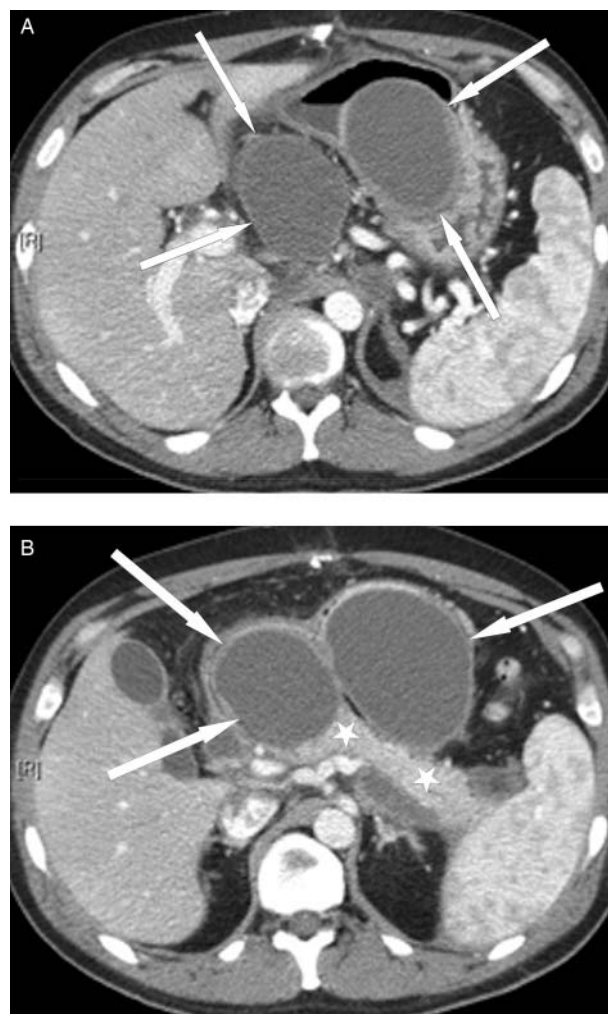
A 40-year-old man with two pseudocysts in the lesser sac 6 weeks after an episode of acute interstitial pancreatitis on CT (A, B). Note the round to oval, low-attenuated, homogeneous fluid collections with a well defined enhancing rim (white arrows pointing at the borders of the pseudocysts), but absence of areas of greater attenuation indicative of non-liquid components. White stars denote normal enhancing pancreas.
